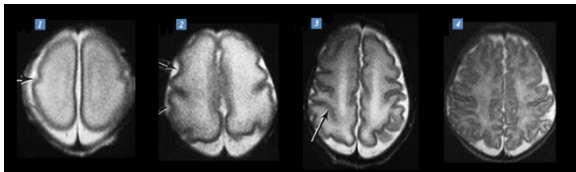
MR images of a preterm infant born at the 25th, 28th, 32nd and 40th week of gestational age (GA). The MR images are taken at a supraventricular level in the transverse plane. [13]
